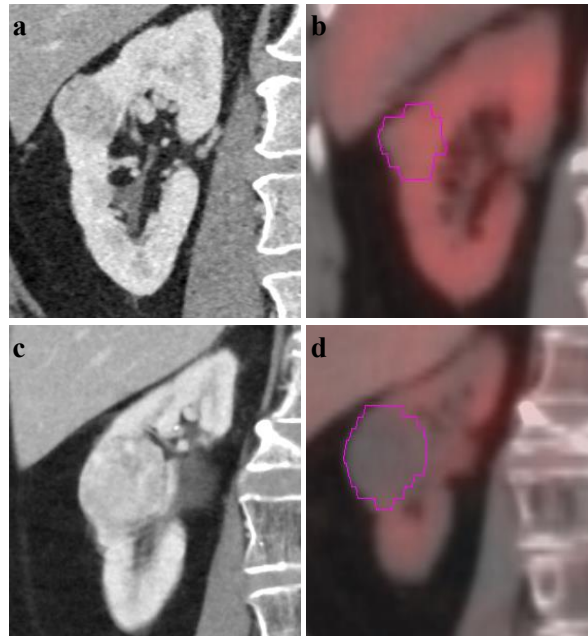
a) postcontrast CT image of a patient with *Oncocytoma*, b) ^{99m}Tc -sestamibi SPECT/CT scan of the patient shows high uptake, c) postcontrast CT image of clear cell RCC (CCRCC), d) ^{99m}Tc -sestamibi SPECT/CT scan of the same patient shows cold uptake.
